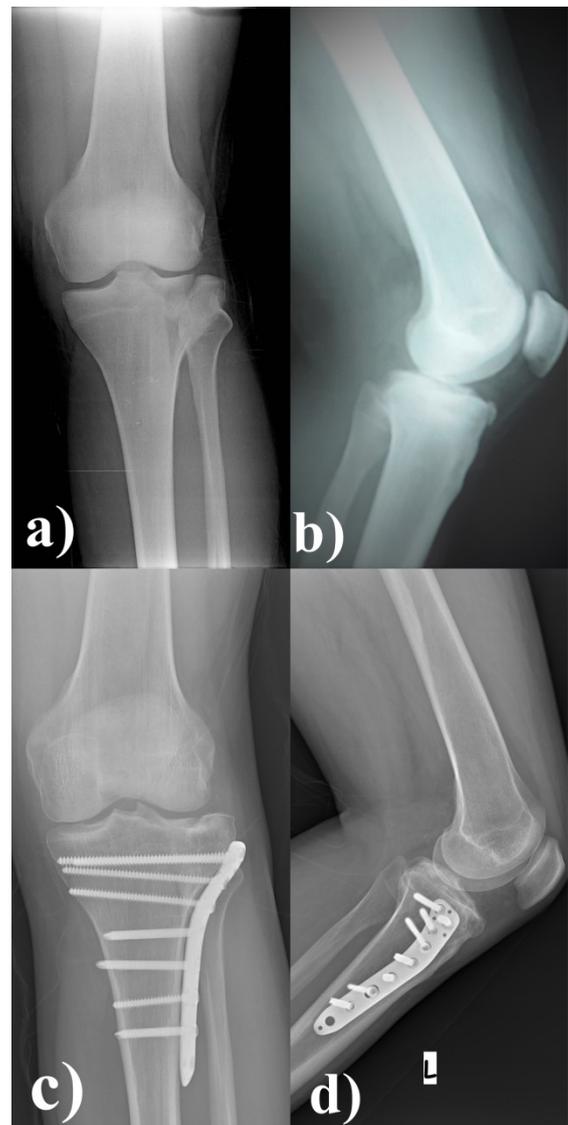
Tibial plateau Schatzker type II fractures treated with open reduction and locked plate fixation: Preoperative and postoperative appearance; a) anterior posterior, b) lateral radiography (respectively).
